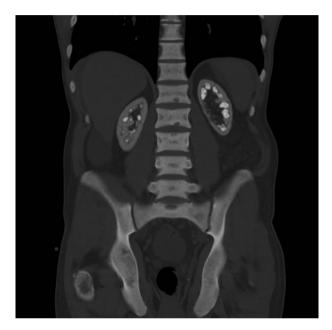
CT scan abdomen and pelvis coronal view.
